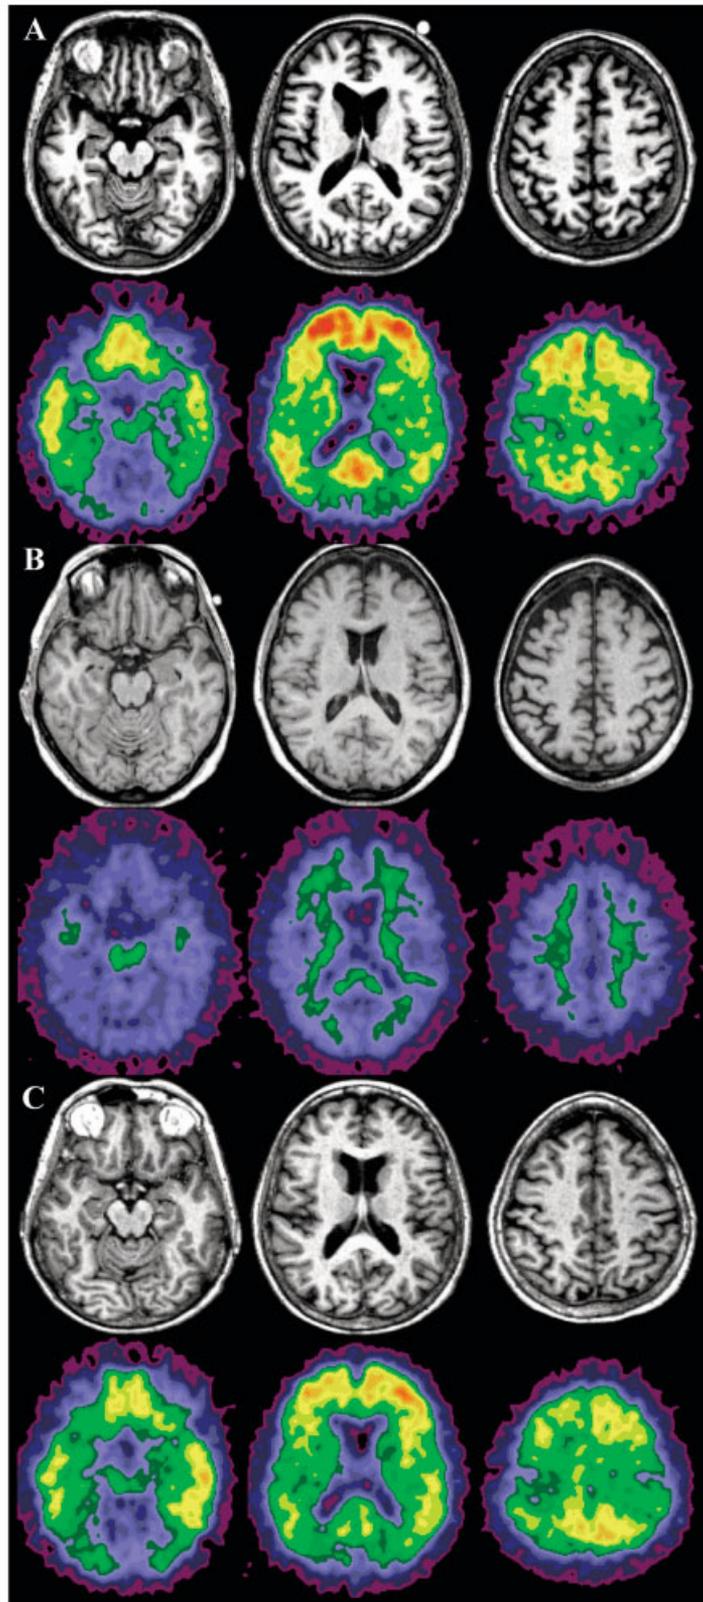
Distribution of Pittsburgh Compound-B (PIB) in three subjects as viewed by positron emission tomography (PET). For each subject, the three magnetic resonance (MR) images (black and white) are at three different levels above the anterior commissure–posterior commissure line. The PET images (in color) are taken from the same levels as the MR images and reflect the PET activity summed from 30 to 60 minutes after injection of PIB. PET data were scaled to normalize for activity in the cerebellar cortex. (A, C) Increased binding of PIB in many brain regions in these two subjects, particularly the prefrontal cortex, the medial and lateral parietal cortex, and the lateral temporal cortex (PIB-positive), is shown. (B) Only low levels of nonspecific PIB binding in white matter structures in this subject and no evidence of binding in cortices (PIB-negative) are shown.
